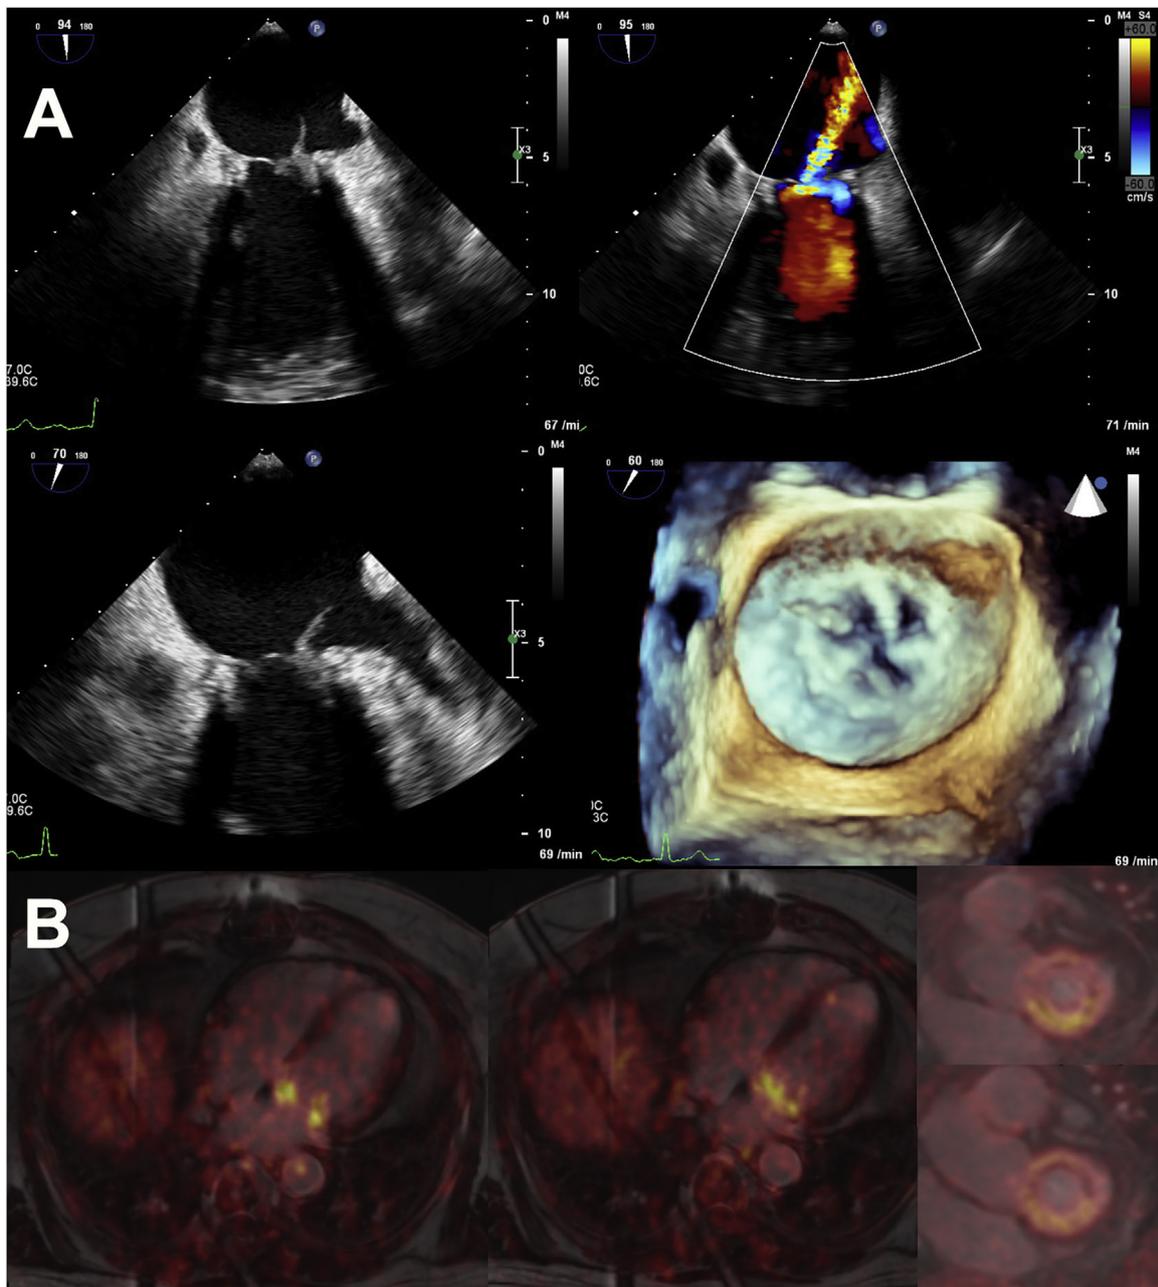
Prosthetic valve endocarditis of the biological mitral valve with vegetation. (A) Vegetation on the biological prosthesis (leaflet) in 2D and 3D transesophageal echocardiography with significant mitral insufficiency. (B) Positron emission tomography/magnetic resonance imaging showing inflammation of the biological prosthetic mitral valve.
